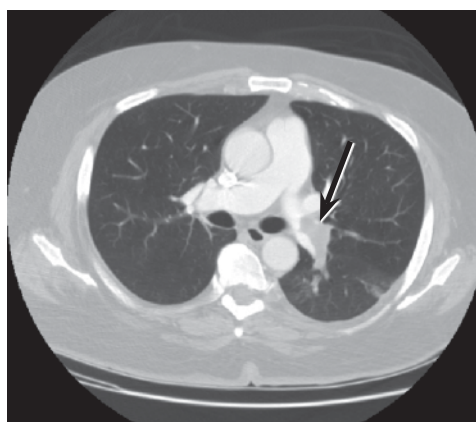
Chest spiral computed tomography demonstrating a 3.1-cm pulmonary embolus in the left main pulmonary artery extending into the left inferior pulmonary artery (arrow) with a left-sided pulmonary infarct.
